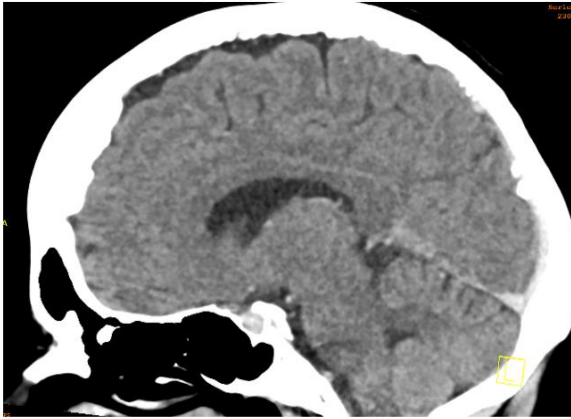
CT pituitary; pituitary gland appears normal in size with no evidence of pituitary macroadenoma
